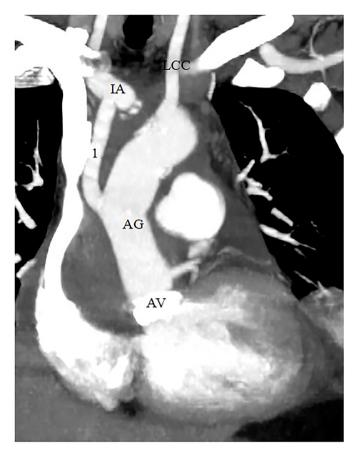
Using the innominate artery (IA) cannulation graft for proximal arch repair. Computed tomography angiography showing that the graft used for IA cannulation was anastomosed between the ascending aortic graft (AG) to IA in a patient who underwent Bentall and proximal arcus repair operation. AV=aortic valve; LCC=left common carotid artery; 1=graft to IA.
